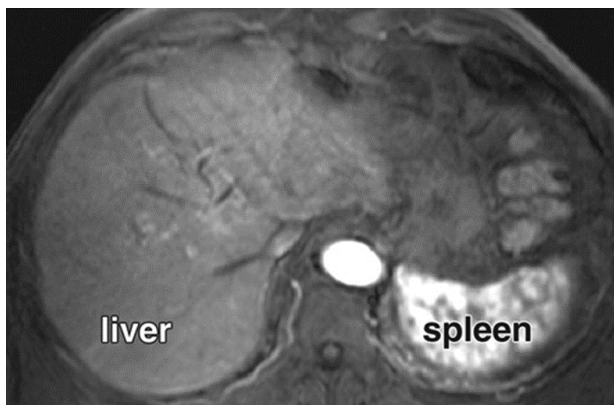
Axial 3D arterial phase GRE T1-weighted image obtained with bolus tracking shows no pathologic findings. This sequence is the single most important sequence for the detection and characterization of focal liver lesions. (16)
